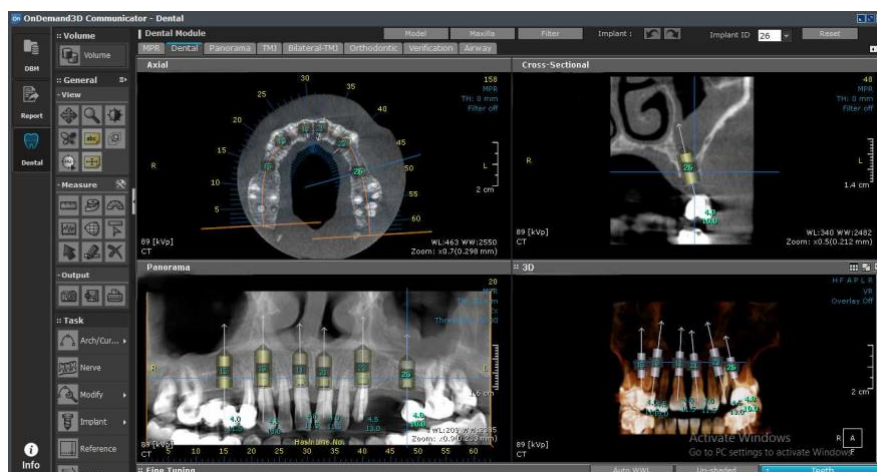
Initial situation on the CBCT
